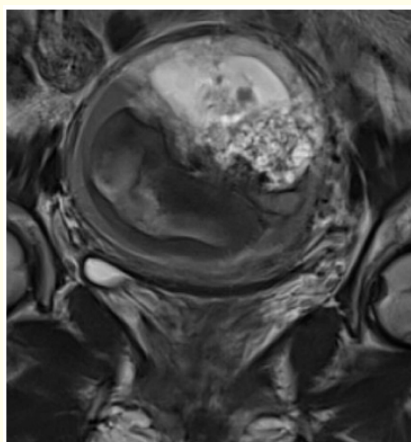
Pelvic MRI showing no signs of myometrial invasion.
